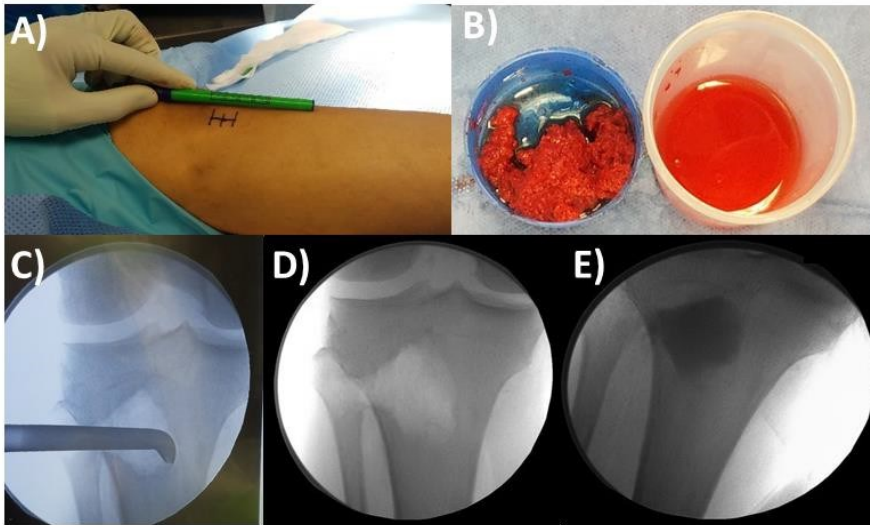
A) 2 cm incision site over anterior proximal tibia. B) Collected autologous bone graft (left) and bone marrow aspirate (right). C) Radiograph with curved, beveled tip of aspirator in the proximal tibia. D) Radiograph of proximal tibia post-harvest. E) Radiograph of bone substitute backfilled proximal tibia harvest site.
